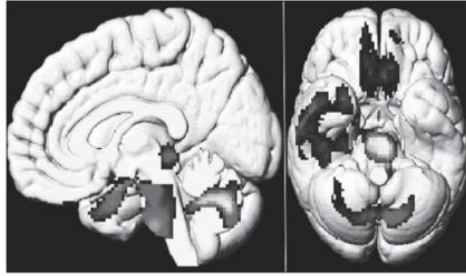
18F-FDG brain PET hypometabolism in patients with long-term COVID. Compared to healthy subjects, patients show hypometabolism in the cerebral cortex, including the olfactory gyrus, right temporal lobe, amygdala, and hippocampus, and extending to the thalamus, pons, medulla oblongata, and cerebellum (p-oxel <0.001 uncorrected, p-cluster <0.05 with FWE correction; SPM8 3D rendering).
